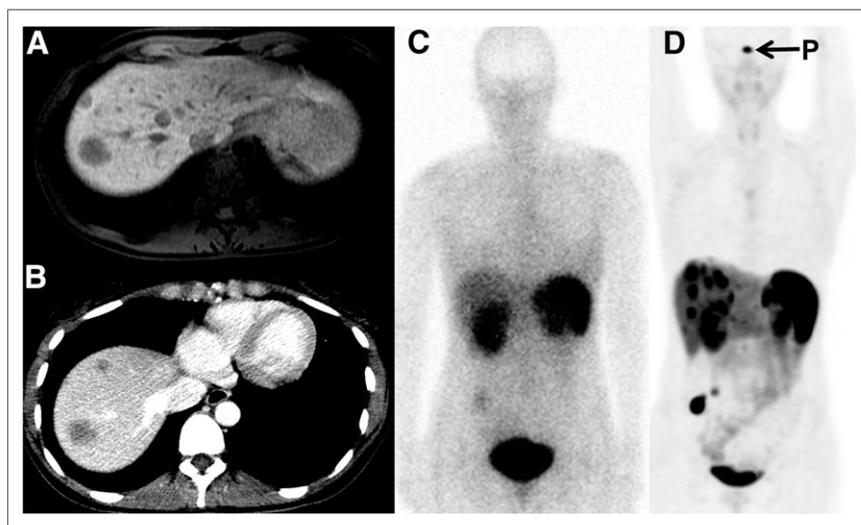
Axial gadoxetate disodium (Eovist; Bayer) MRI (A) and intravenous contrast-enhanced CT (B) images reveal some of the widespread metastatic disease in liver. Anterior planar ^{111}In -pentetreotide scan (C) and SPECT/CT (not shown) demonstrate uptake only in primary ileal tumor in abdominal right lower quadrant. On the basis of these findings, the patient would not be a candidate for PRRT treatment. ^{68}Ga -DOTATATE PET/CT (only 3-dimensional anterior maximum-intensity projection shown in D) demonstrates intense uptake in primary tumor, a locoregional node, and liver metastases, showing that patient has sufficient somatostatin receptor expression to qualify for PRRT, among other treatments. Arrow indicates normal pituitary uptake (P).
